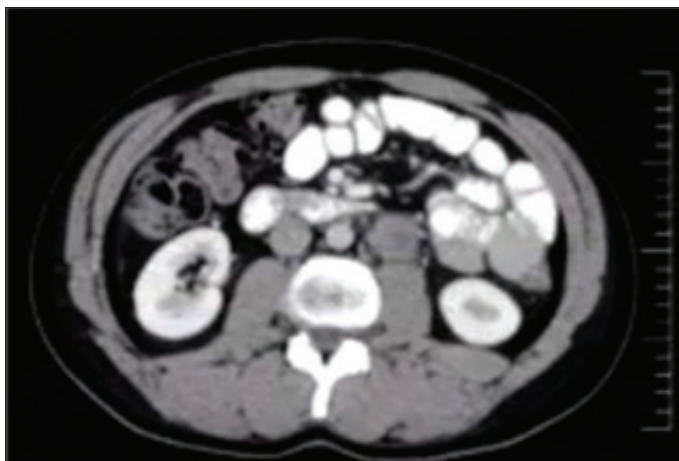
Case 2: Stage 2B non-seminoma. Computed tomography demonstrating 4.5 cm left para-aortic lymph node.
